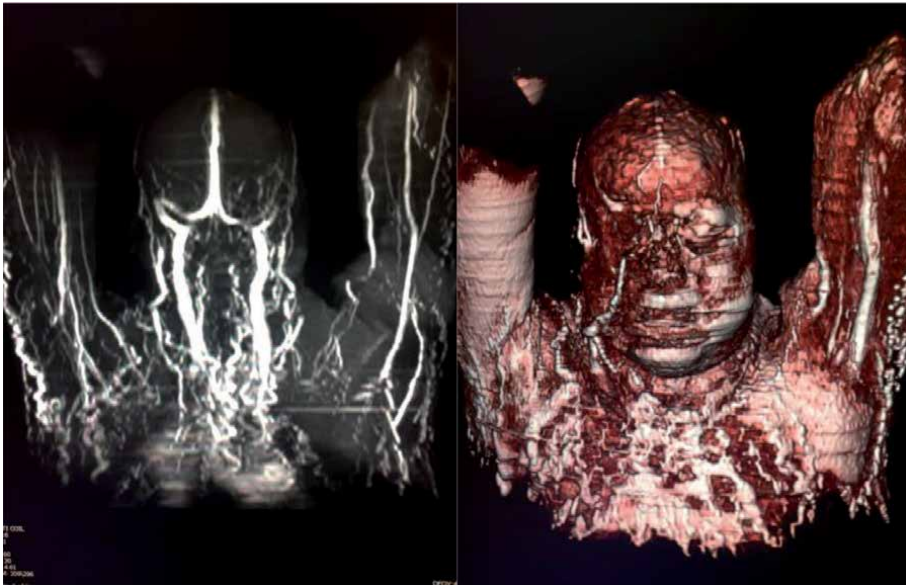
MRI using TOF protocol, without contrast, to have venous mapping prior to intervention, in a patient who was grossly edematous and had no veins available to perform CT venography. It showed multiple levels of CVS, including bilateral IJVs, EJVs, and bilateral BCVs.
